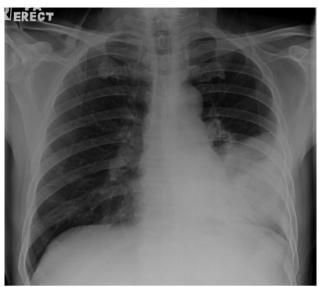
(a) Initial chest x-ray was normal. (b) Chest x ray showing progressive consolidation and effusion up to mid zone of left lung over two weeks duration.
